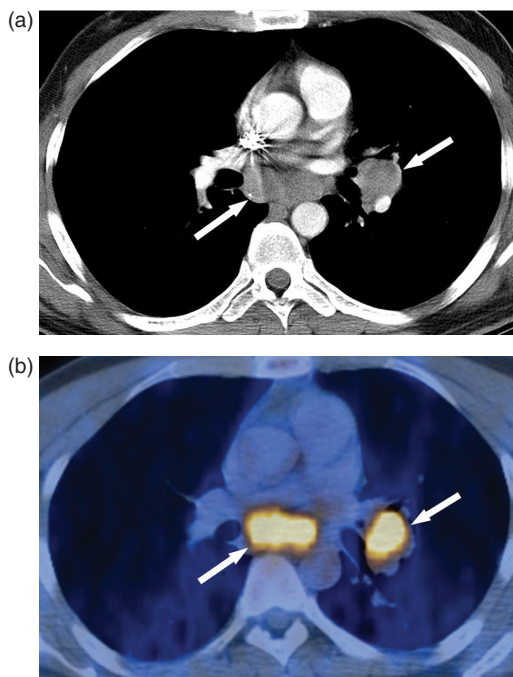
A 39-year-old woman with small cell lung carcinoma (limited disease). (a) A mediastinal window image of a transverse contrast-enhanced CT scan (5-mm section thickness, 130 mAs) obtained at the subcarinal area shows an enlarged lymph node in the subcarinal and left hilar areas (arrows). (b) Integrated PET/CT scan shows high FDG uptake (arrows) within the nodes (SUV_{max} , 15.7).
